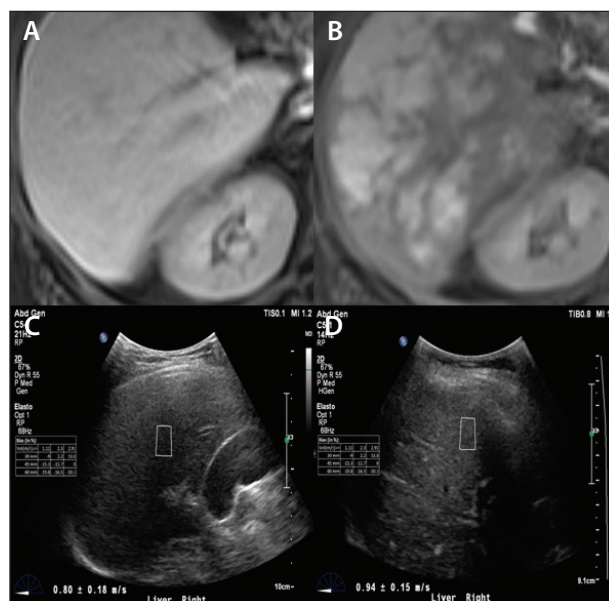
MRI and ultrasound point shear wave elastography (PSWE) after Y-90 SIRT. Eovist MRI before and after Y-90 SIRT demonstrating prominent fibrotic changes following right liver lobar radioembolization (A, B). Ultrasound-based PSWE within the areas of apparent fibrosis on MRI before and after Y-90 SIRT (C, D). No significant changes were apparent in fibrosis indices before and after the procedure, despite the robust appearance of bridging fibrosis on MRI (PSWE mean cutoff values, 2–4.5 kPa for METAVIR F0 [normal]; 4.5–5.7 for F0–F1 [normal to mild]; 5.7–12 for F2–F3 [mild-moderate]; 12–21+ for F3–F4 [moderate-severe]).
